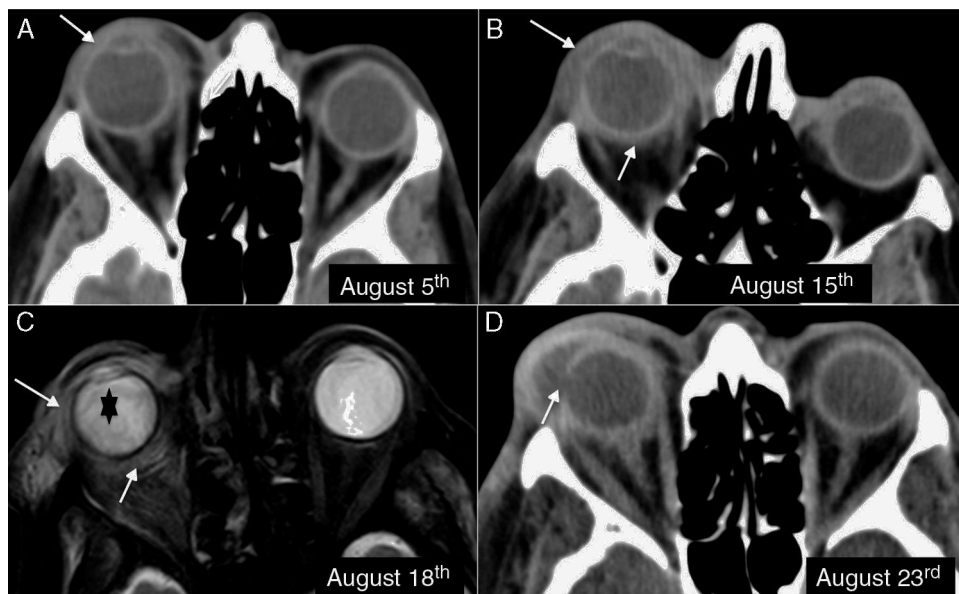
Scleritis with posterior development of endophthalmitis. (A, B and D) Axial computed tomography of the orbits. (C) T2-weighted MRI axial section with fat saturation. Diabetic patient who the 5th day presented with pain, proptosis and right eye redness. There is an increase of preseptal soft parts (arrow in A) interpreted as orbital pseudotumor. Corticoid and antibiotic treatment is started, but the condition progresses clearly observing greater affection of the bulbous covers (arrows in B) an even inflammatory affection of the intra- and extraconal fat (arrows in C). Also there is an unreported loss of the right vitreous signal (asterisk in C). Finally, the progression of the process led to the development of a peribulbar abscess (arrow in D). Diagnosis after the microbiological study was endogenous or metastatic endophthalmitis secondary to *Escherichia coli*.
